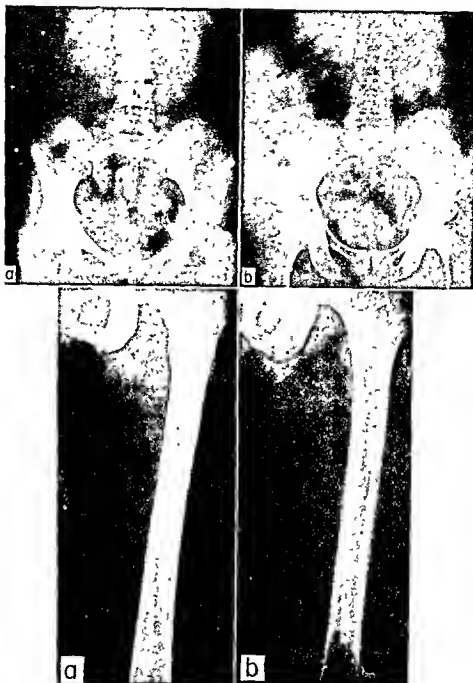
Roentgenograms of the spine, hip bones, and femur of a woman with myelofibrosis (a), compared with those of a normal woman of the same age (b). Note especially the striking contrast between the density of the vertebrae and of the spongiosa of the long bones in the two subjects.
